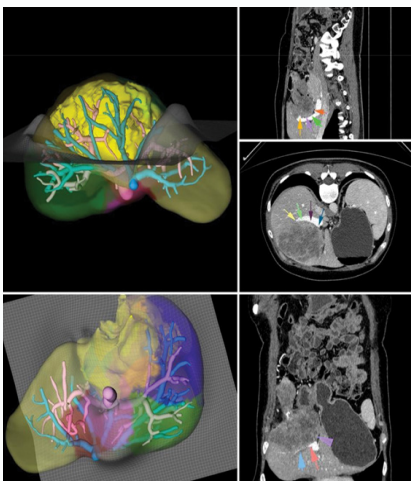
D and 3D CT imaging of the patient after 3 months of CTx.
